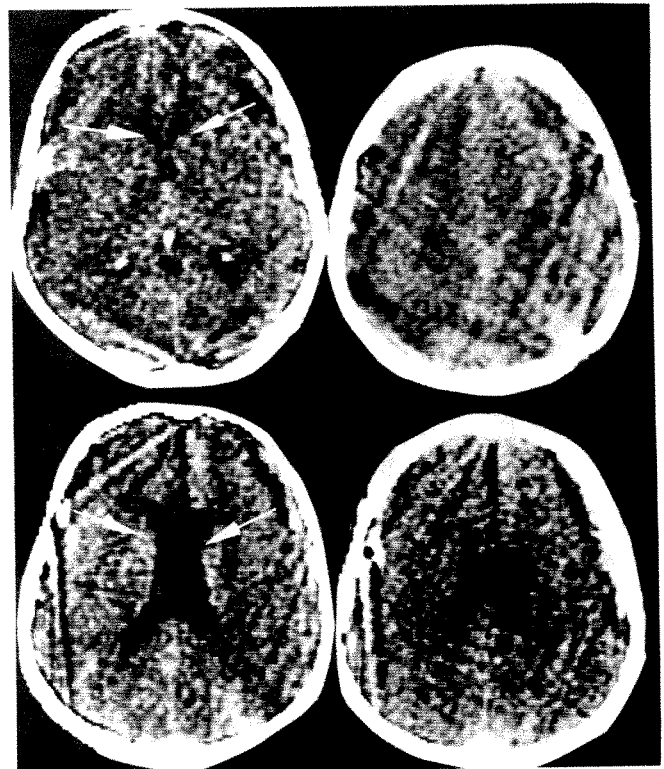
Bilateral subdural hematomas. Upper, Small ventricles (arrows) and no evidence of subdural hematoma on preoperative scan. Lower, Post-operative CT scan after removal of bilateral subdural hematomas showing ventricular reexpansion (arrows) and small reaccumulation on right.
